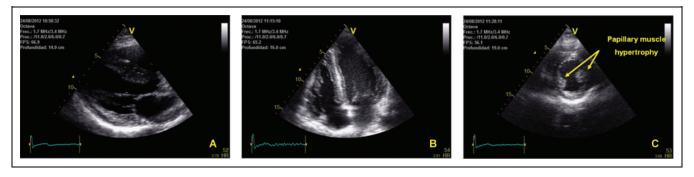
Doppler echocardiography in a patient with Fabry disease. A, Parasternal long axis (left). B, Apical 4-chamber view showing advanced cardiomyopathy with asymmetrical septal hypertrophy. C, Short-axis echo view (right) showing a prominent papillary muscle hypertrophy.
